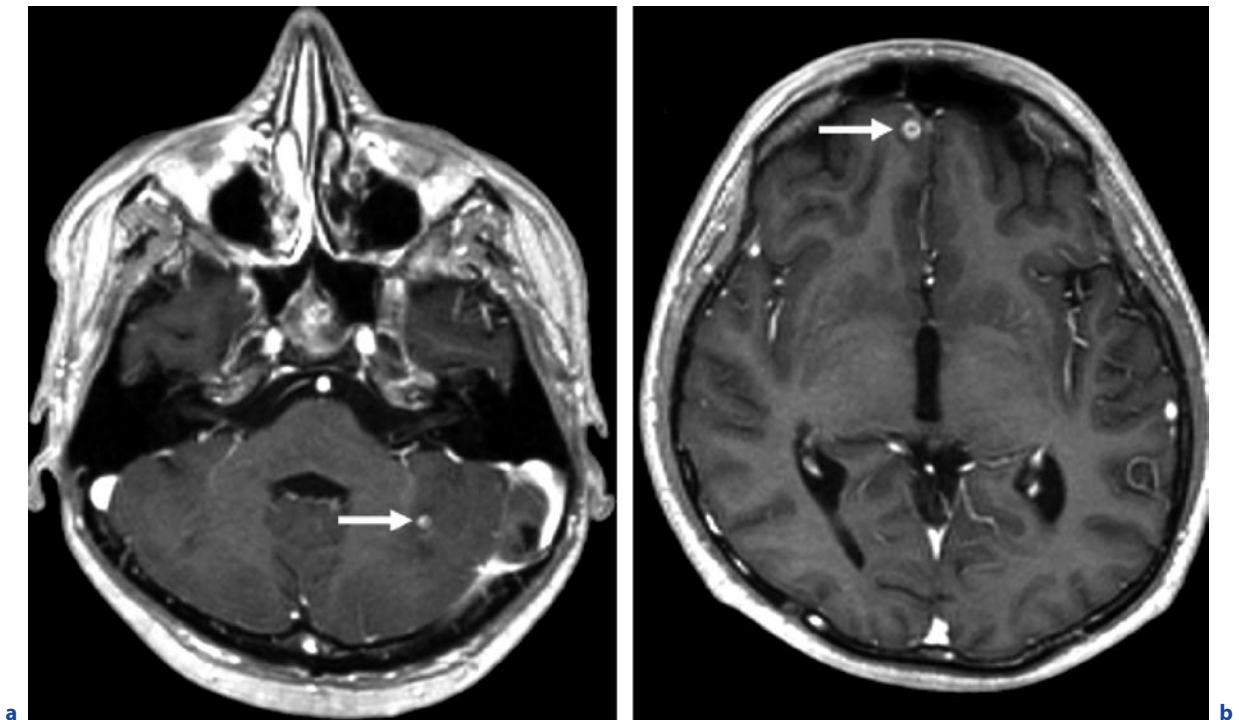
Candida* infection with cerebral microabscesses. a,b Axial T1-weighted images after contrast administration. c,d see next page
